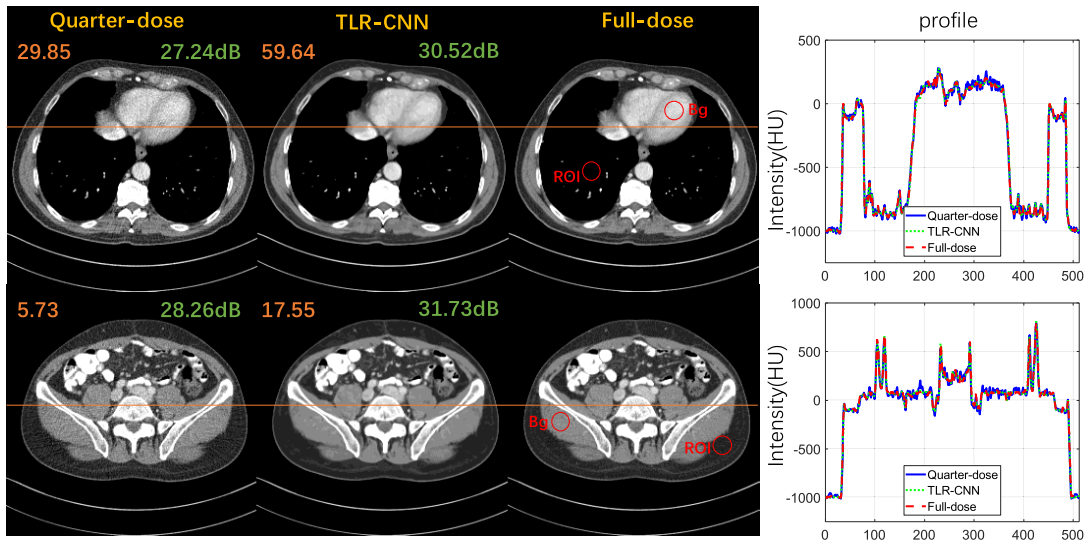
Denoising results from the test data. The first to third columns represent quarter-dose CT, denoised images by TLR-CNN and the full-dose CT, displayed in $[-160, 240]$. And the profiles of the corresponding positions are plotted in the fourth column.
